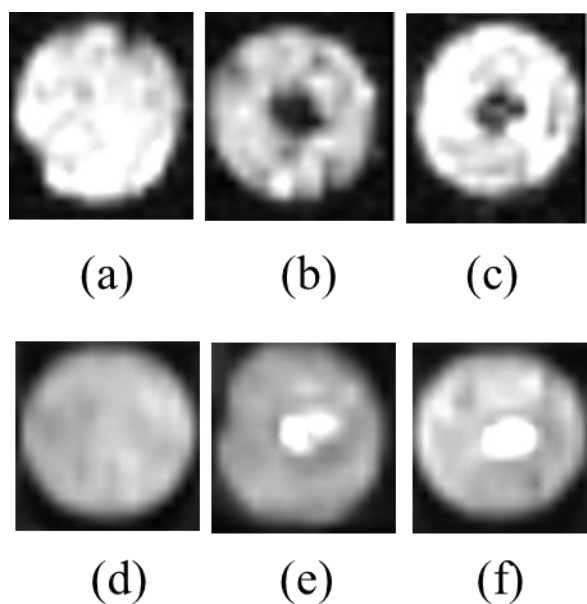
MRI images of Lipid/PNIPAM system.
